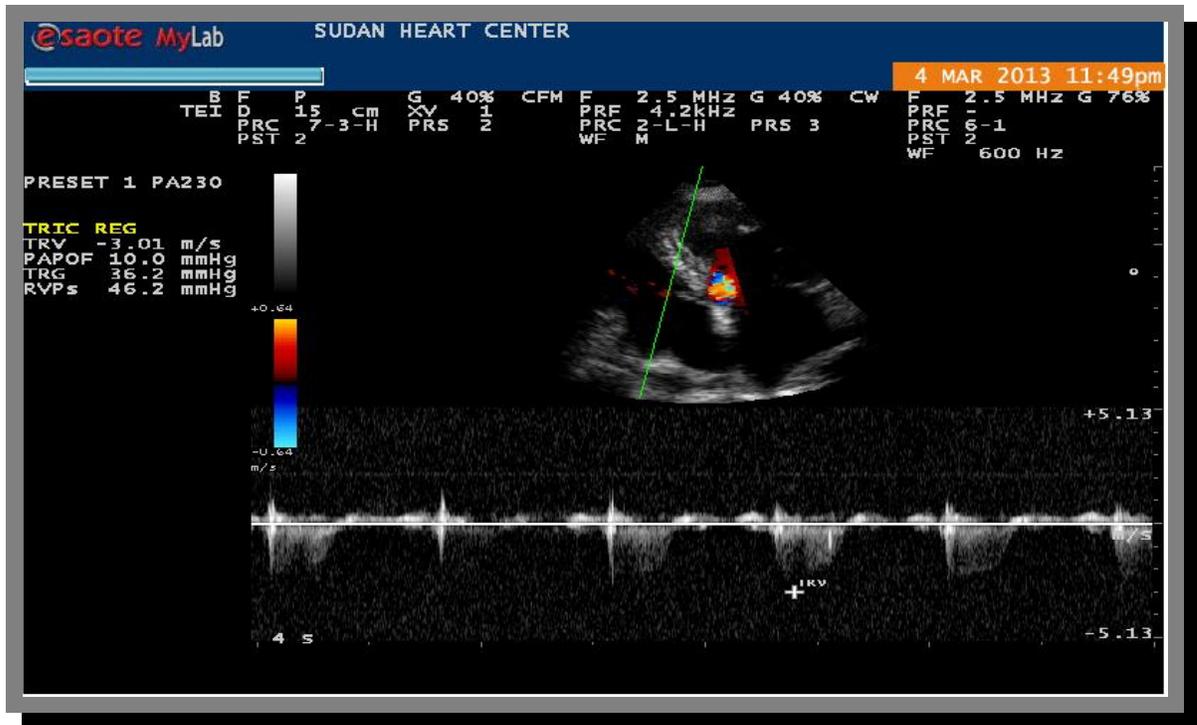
Continuous wave Doppler signal of tricuspid regurgitation with a peak velocity of approximately 3.01 m/s.
